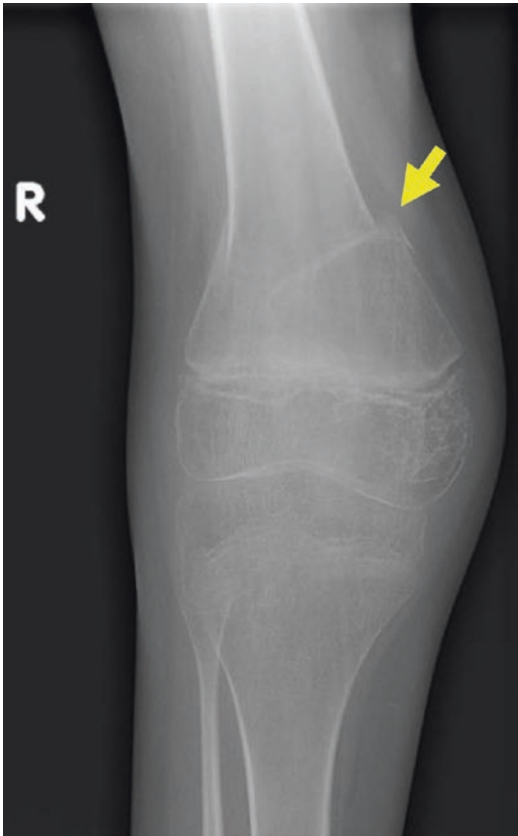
Radiograph of the right knee of a 16-year-old boy with severe osteopenia. The *yellow arrow* indicates a fracture of the femur
